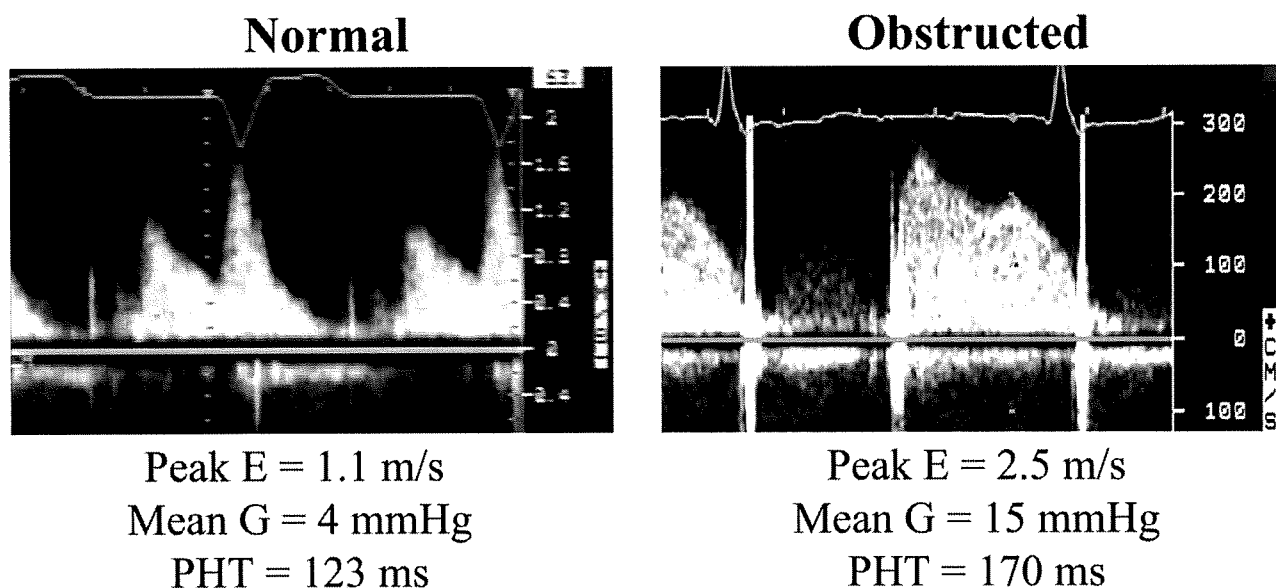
Doppler velocity patterns observed in a normal and an obstructed prosthetic valve in the mitral position. The velocity and gradients are elevated as well as pressure half-time in the obstructed valve.
